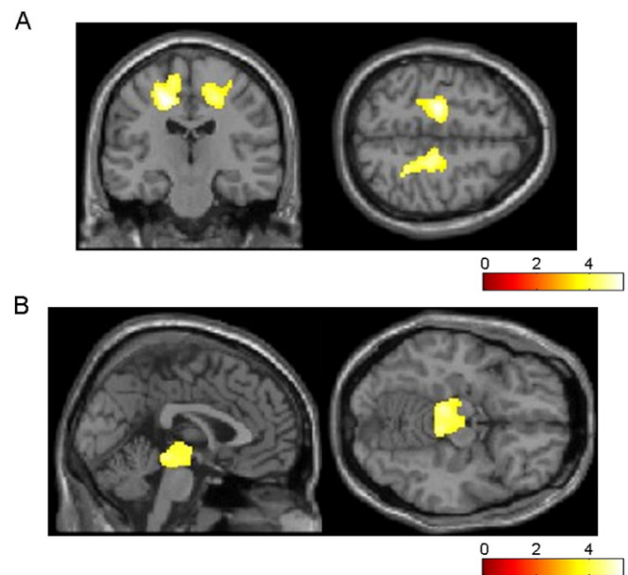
Regions of WM reduction in CBS (A) and RS (B) patients relative to the others. More atrophic lesions are found in 9 CBS patients than in 17 RS patients, especially in the bilateral cingulate, right postcentral, and right middle frontal gyrus (A). On the other hand, significant atrophy is observed in the bilateral midbrain in RS patients (B). Significance maps of WM reduction in CBS and RS patients are superimposed on a T1-weighted brain MRI template image in the Montreal Neurological Institute space. The color bar represents the t value.
